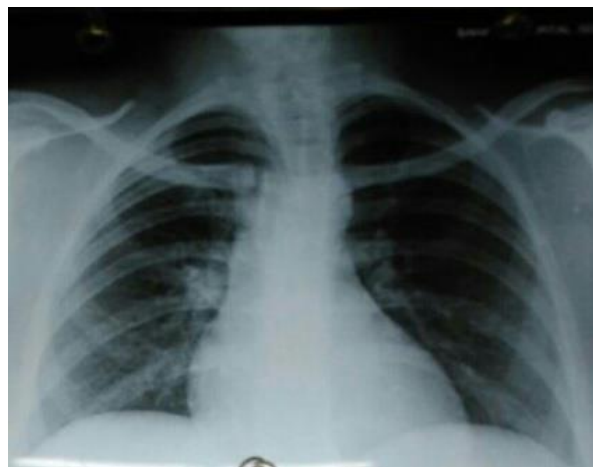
Chest X-ray PA view suggestive of bilateral hilar lymphadenopathy
